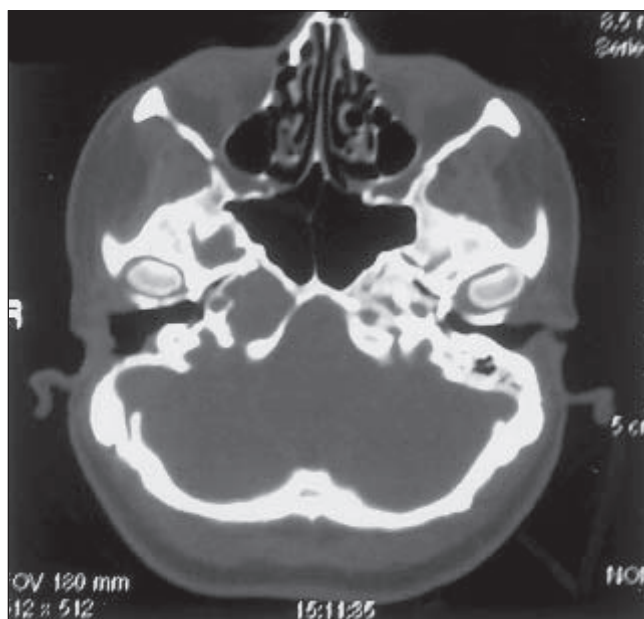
CT scan showing a large petrous apex cyst.
